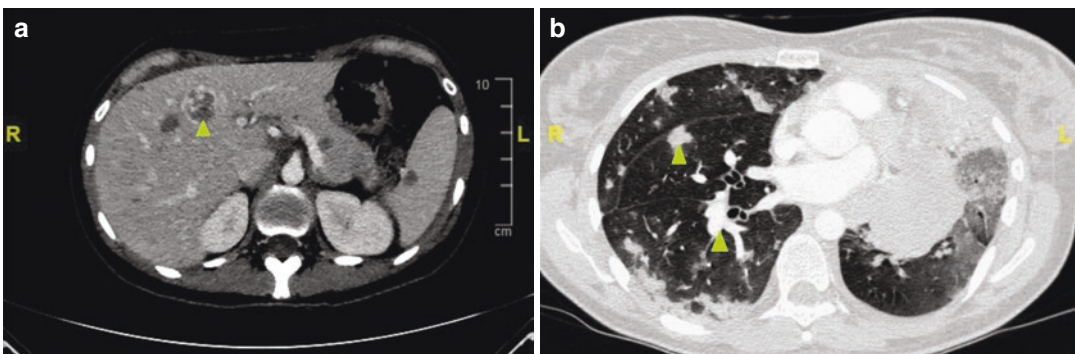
Liver (a) and chest (b) computed tomography of a patient with metastatic gestational choriocarcinoma. Green arrowheads indicate liver and lung metastases
